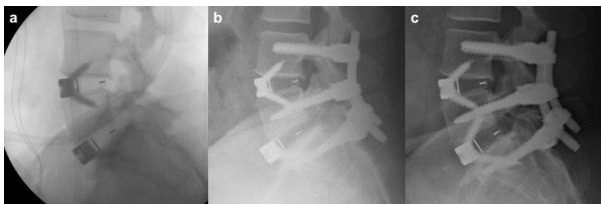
Single patient requiring revision of the implant. (A) Intraoperative radiograph after index anterior procedure showing implant fixation with S1 screws and good opposition of the implant on L5 with a residual spondyloolisthesis. (B) After placement of posterior instrumentation and anatomic reduction of L5 on S1, the implant appears to have migrated but is in fact stable in position on S1 with loss of contact with L5. (C) Repeat postoperative radiograph after L5-S1 implant revision with the addition of L5 fixation. Anatomic reduction of L5 on S1 with full implant contact with both vertebrae has been achieved.
